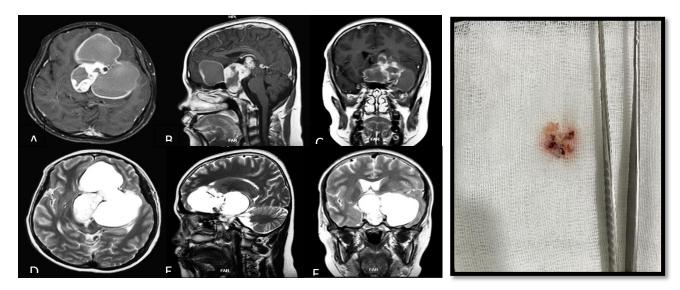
MRI brain of Case no. 3. (A) T1 axial with contrast, (B) T1 sagittal with contrast, (C) T1 Coronal with contrast, (D) T2 axial, (E) T2 Sagittal, (F) T2 Coronal, (G) Mass of Tumor Removal from case no. 3
